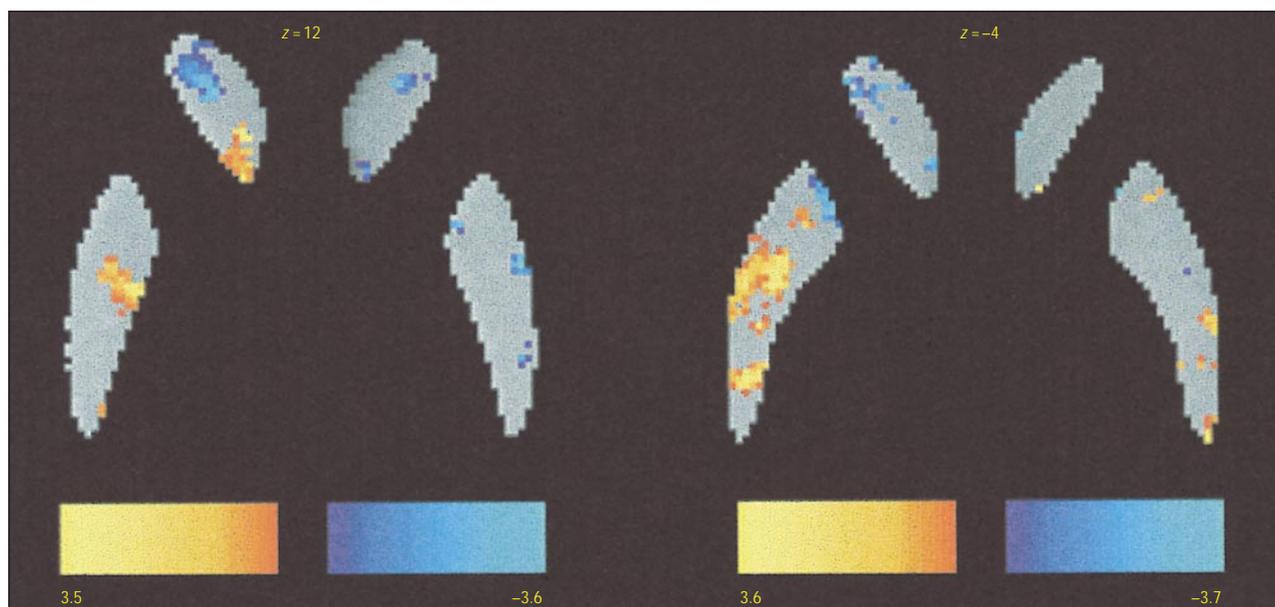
Caudate and putamen relative metabolic rate in patients with schizotypal personality disorder and schizophrenic patients who never received medications (ie, never-medicated patients). The dorsal ($z=12^{21}$) and ventral ($z=-4$) caudate and putamen are shown on a background of the mean shape-standardized magnetic resonance image on which they were traced. The color bar represents t values comparing relative metabolic rate in patients with schizotypal personality disorder and schizophrenic patients. The red-orange-yellow color bar extends from red ($t_6=2.12$, $P=.05$, 2-tailed) to the maximum light yellow value at 3.5 to 3.6 ($P<.003$). Red represents the significantly higher metabolic rate in the patients with schizotypal personality disorder than in the schizophrenic patients and is consistent with the analysis of variance (see “Results” section and Table 2). The violet-purple-light blue bar is similarly arranged for the schizophrenic patients and is greater than for the patients with schizotypal personality disorder. Left side of the brain is on the right side of the image.
